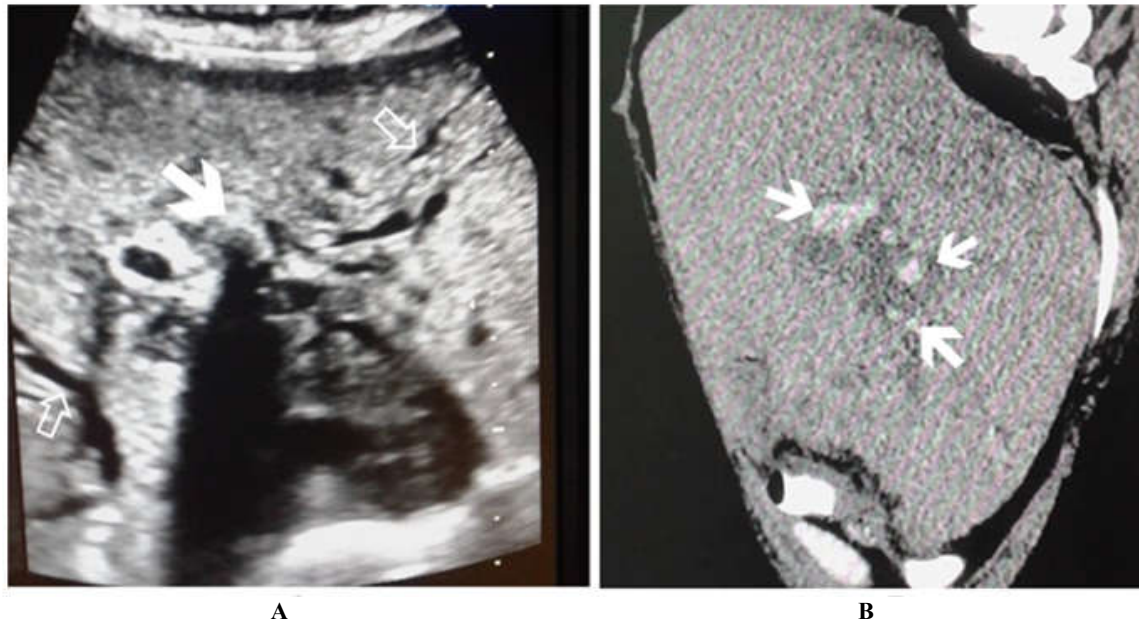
(A) Ultrasound image of upper abdomen show calculus at biliary confluence (solid arrow) with dilated bilobar intrahepatic biliary radicals (open arrow). (B) Sagittal reformatted CT image of the liver showing multiple hyperdense biliary calculi (solid arrows) with dilated biliary radicals
